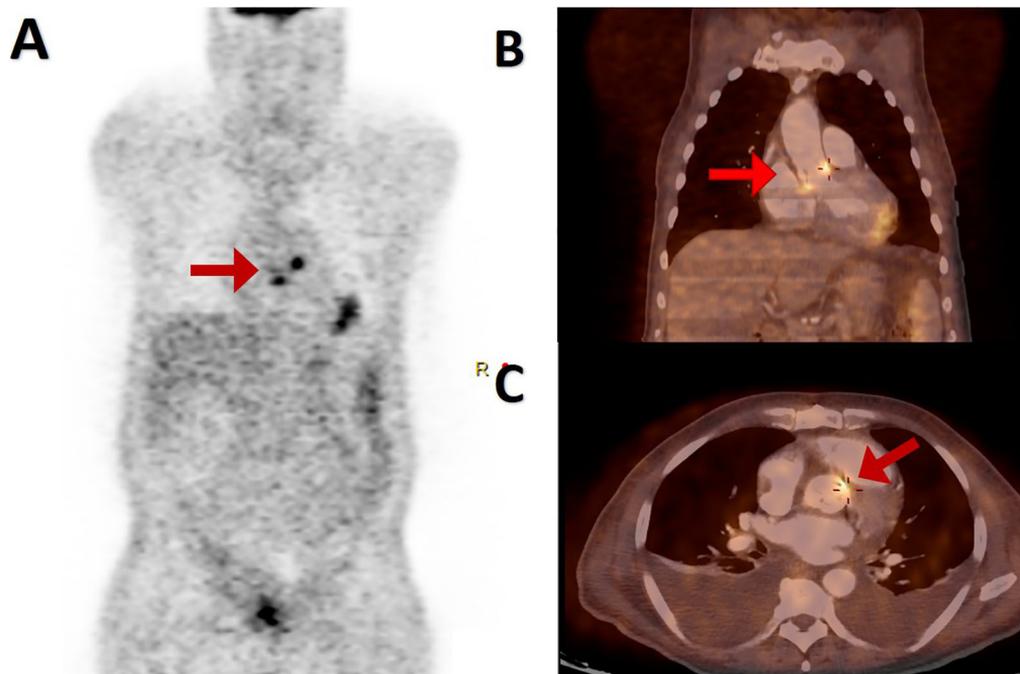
Multimodal image: (A) ^{18}F -FDG PET images. (B) Coronal PET-CT image. (C) transaxial PET/CT image. The images revealed a focal peri-prosthetic uptake in the aortic valve (Red arrow) with a maximum standardized uptake value ($\text{SUV}_{\text{max}} = 8 \text{ g/ml}$), suggestive of an infective endocarditis.
